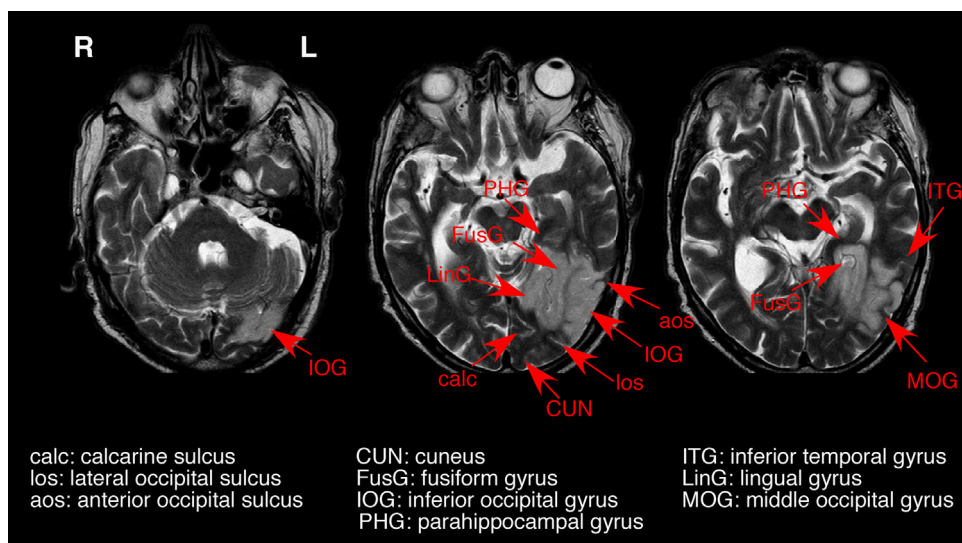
T2-weighted structural MRI showing the extent of AL’s vascular lesion (left hemisphere shown on the right side).
